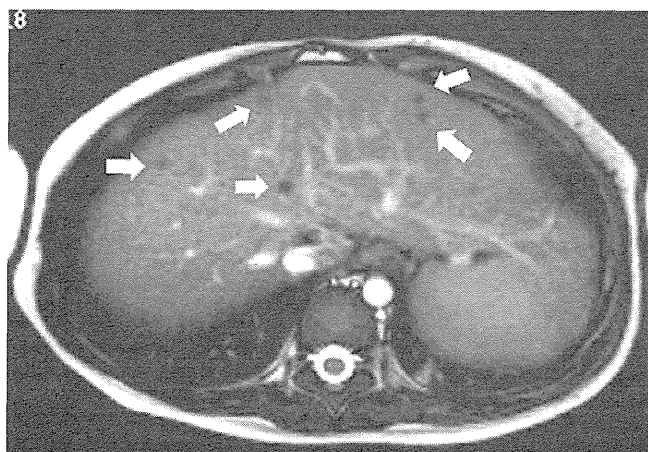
Abdominal magnetic resonance image obtained at 1 year and 4 months shows multiple nodules (arrows) varying in size in the liver, which presented as a low-intensity area on T2-weighted imaging.
